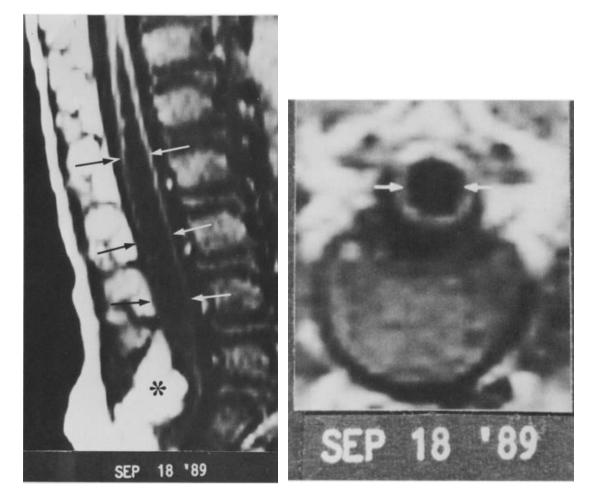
displays another MRI scan, taken when the baby was 1 year and 8 months old. Again, it's a T1-weighted MRI, with a side view (sagittal) on the left and a front view (coronal) on the right. In this scan, you can see that the pocket of fluid called syringomyelia has gotten even bigger (indicated by arrows). However, the size of the fatty lump inside the spine (marked by an asterisk) has stayed the same.
